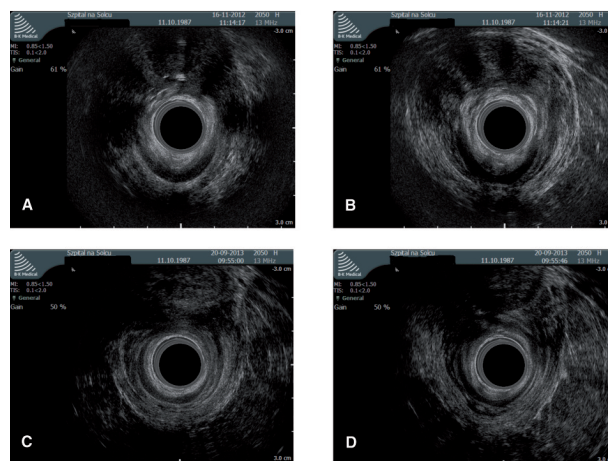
Endosonographic examination of the obstetric injury of the anterior circumference of the internal and external sphincters in mid (A,C) and high (B,D) anal canal, before repair (A,B) and after sphincteroplasty (C,D) showing restored continuity of the muscles.
